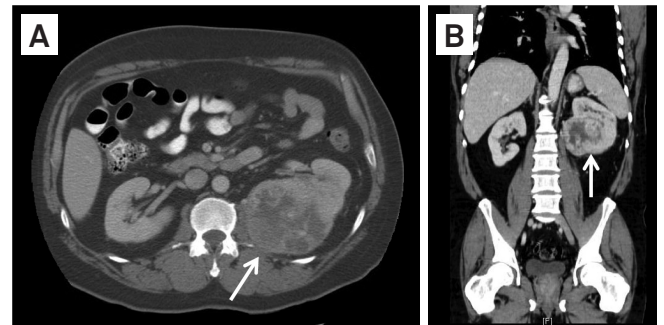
Computed tomography of the chest, abdomen, and pelvis with contrast, axial (A), and coronal reconstruction (B) shows an exophytic peripheral enhancing mass (arrow) arising from the posterior interpolar aspect of the left kidney.
